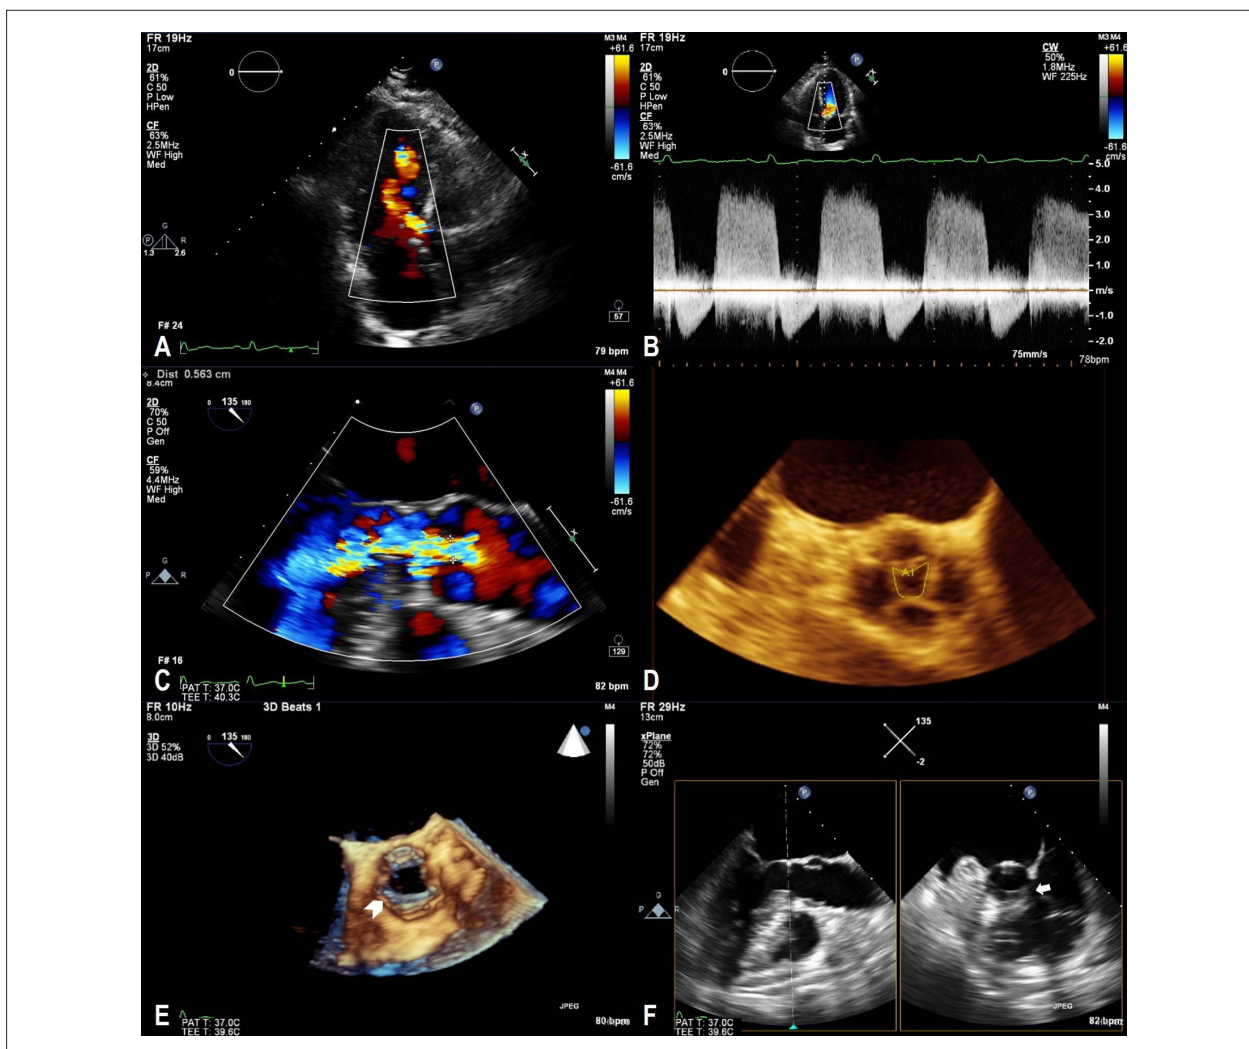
Aortic regurgitation jet visualized by transthoracic echocardiogram with color Doppler (A) and its respective spectrum on continuous Doppler wave (B); large jet visualized by transesophageal echocardiogram, with a 6 mm vena contracta (C), originating from the central coaptation defect of the quadricuspid aortic valve, with a regurgitant orifice of 0.35 cm² in three-dimensional planimetry (D); Almost circumferential thickening of the left ventricular outflow tract readily identified in the three-dimensional image in systole (E), confirming the presence of a subaortic membrane with evaluation of orthogonal planes (F).
